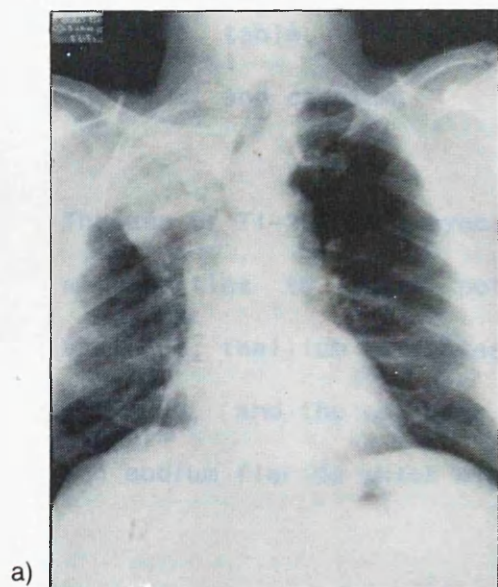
Radiographically a) Chest X-Ray before treatment b) Chest X-Ray after treatment. c & d) C.T. scanning of the same patient pre and post therapy reveal no significant changes in the size of the tumour. The patient showed clinical response to treatment.
